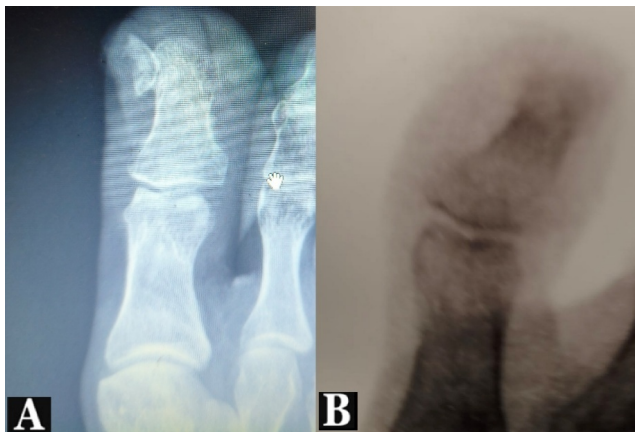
X-ray showing the lesion before excision (A) and the post-excision appearance (B).
